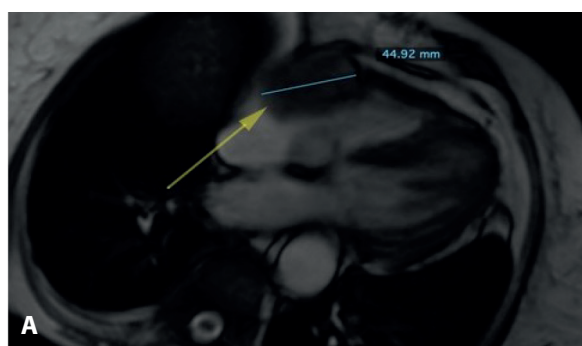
A. MRI: tumor mass with no signs of fat suppression seems strongly connected with the lateral and inferior wall of the right atrium, B. ECHO: right atrium tumor mass 50 x 28 mm connected with the lateral wall of the atrium
